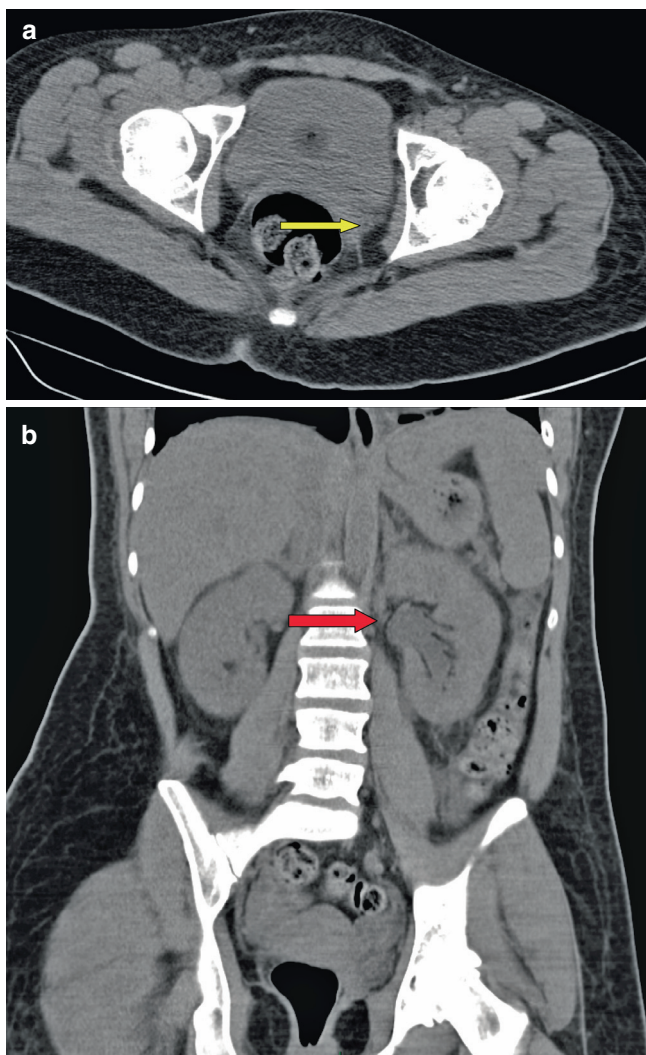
Plain CT KUB showing (a) sloughed renal papilla (yellow arrow) leading to (b) pyonephrosis (red arrow)
